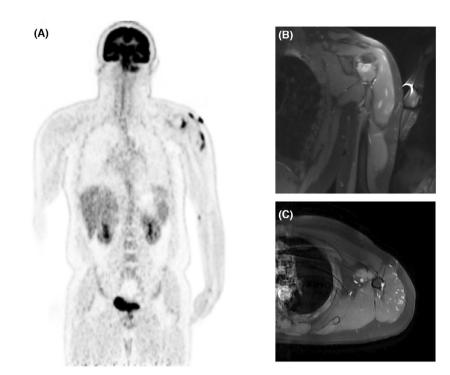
PET-CT imaging showed multifocal FDG-avid lesions in the proximal left humerus and its surrounding intramuscular and subcutaneous tissues (A). MRI demonstrated intense and uniform enhancement following gadolinium administration; T1-weighted enhancement and fat suppression, coronal (B) and axial orientation (C).
